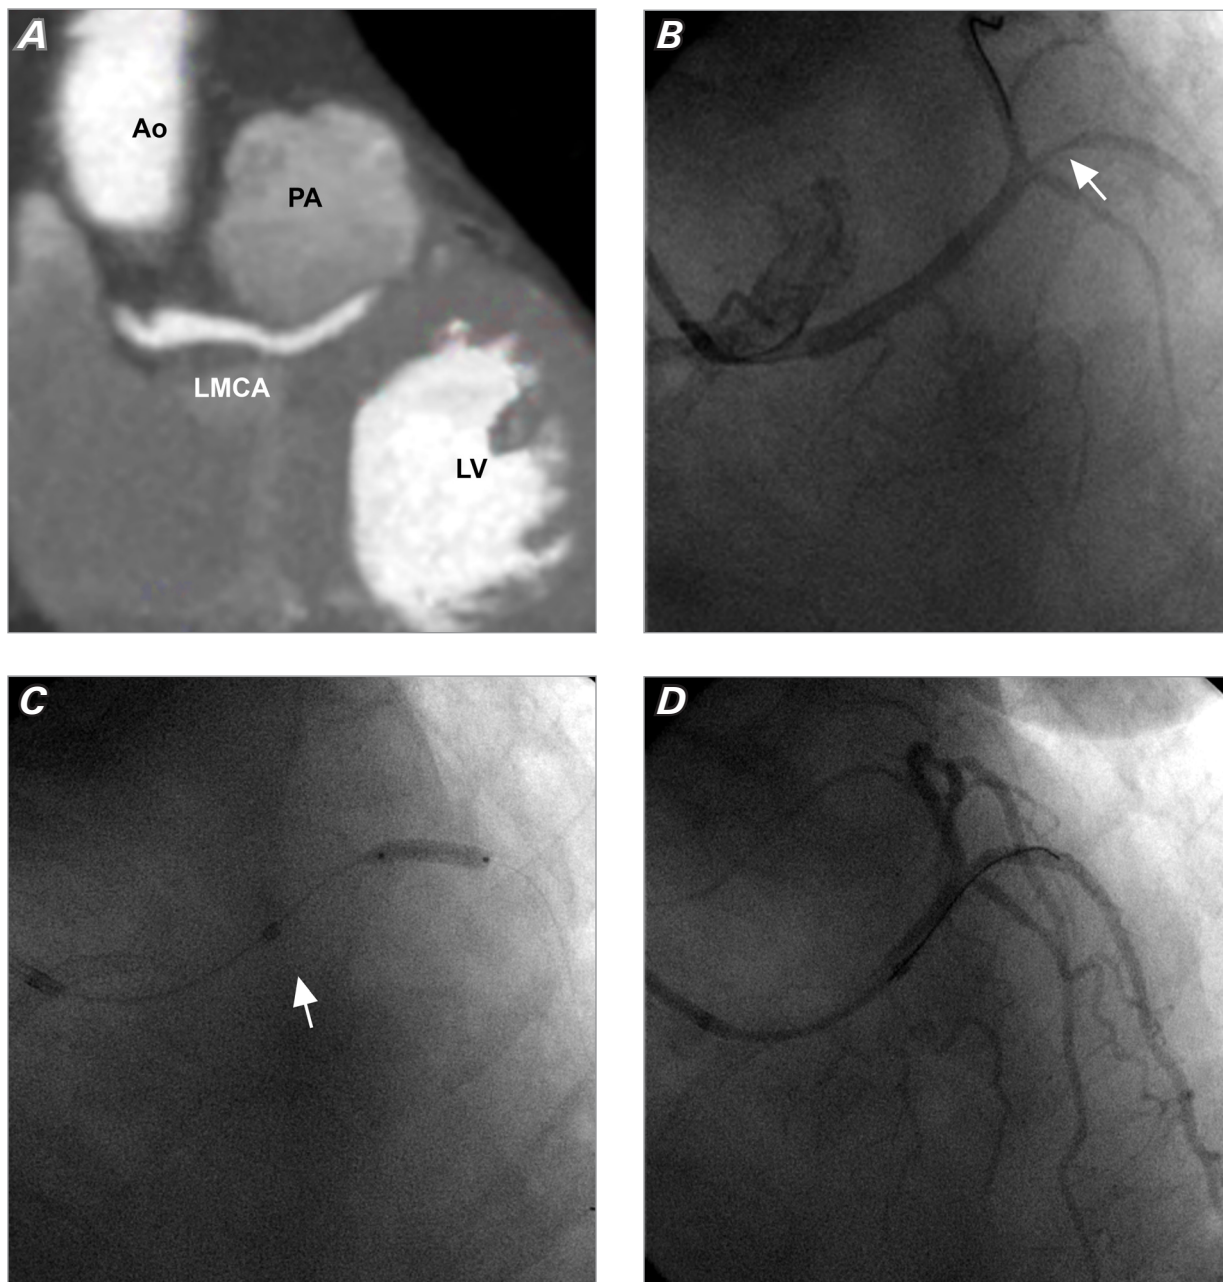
Patient 4. A) A 320-slice cardiac computed tomographic angiogram (sagittal view) shows an anomalous left main coronary artery (LMCA) originating from the right coronary sinus, with an intraseptal path between the pulmonary artery (PA) and the left ventricle (LV). B) Coronary angiogram shows the anomalous LMCA and severe stenosis at the ostium of the left anterior descending coronary artery (LAD) (arrow). Subsequent coronary angiograms show C) a drug-eluting stent implanted with GuideLiner catheter support in the ostial LAD (arrow), and D) the final angiographic result.
